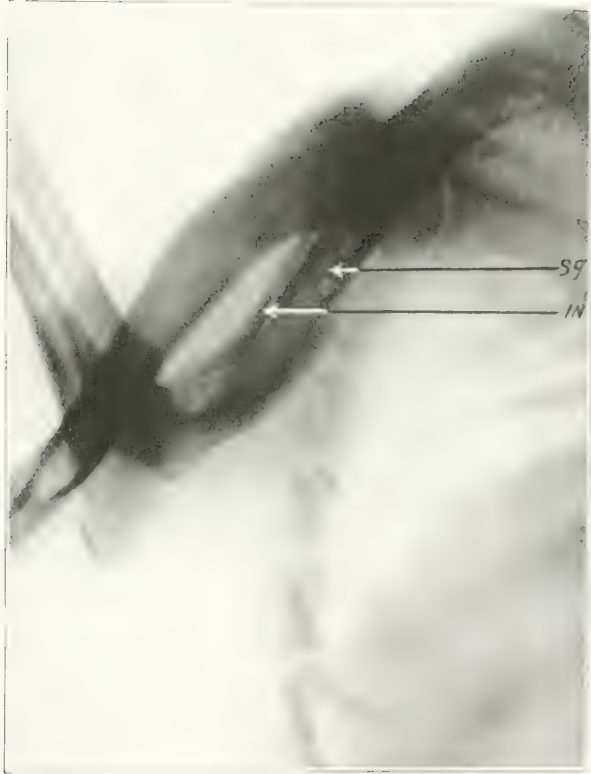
Operation, Oct. 10, 1919; roentgenogram, Nov. 10, 1919; large sequestrum with well-marked involucrum and separation zone: *In*, involucrum; *Sq*, sequestrum. (Figures 1 and 2, also of this case.)
